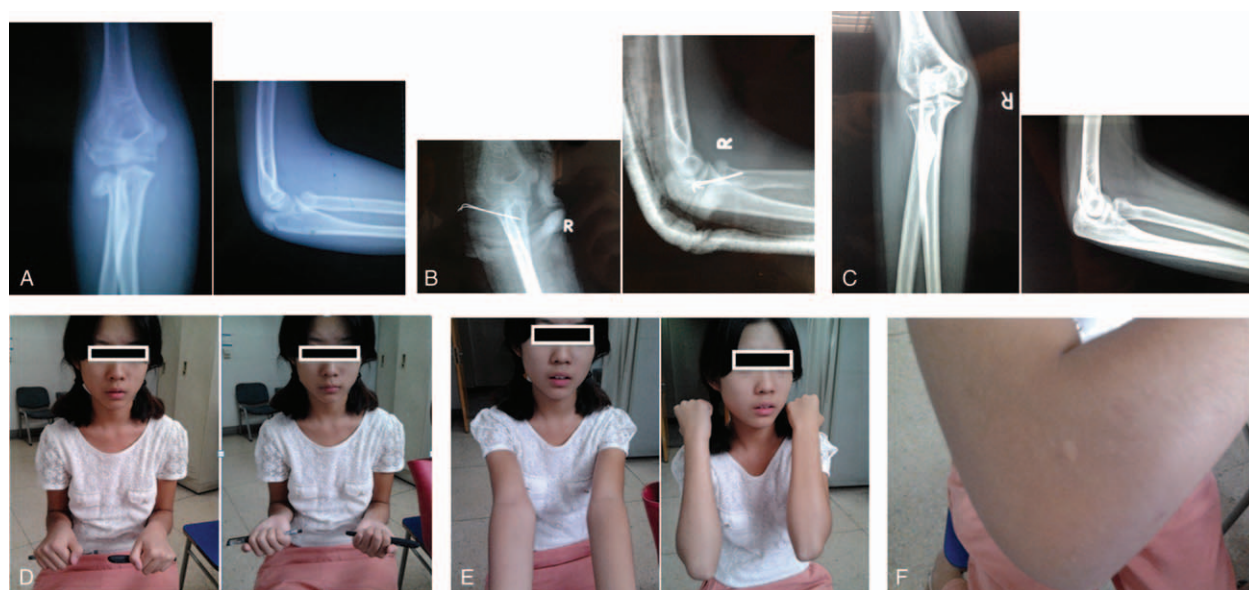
(A) The preoperative X-ray showed the severe tilt and displacement of radial neck. (B) The postoperative X-ray showed the reduction excellent. (C) The 2 years later follow-up X-ray picture showed the radial head normal. (D) The supination and pronation function of the forearm was normal. (E) The flexion and extension function of the elbow was normal. (F) The scar of the needle site was very small.
